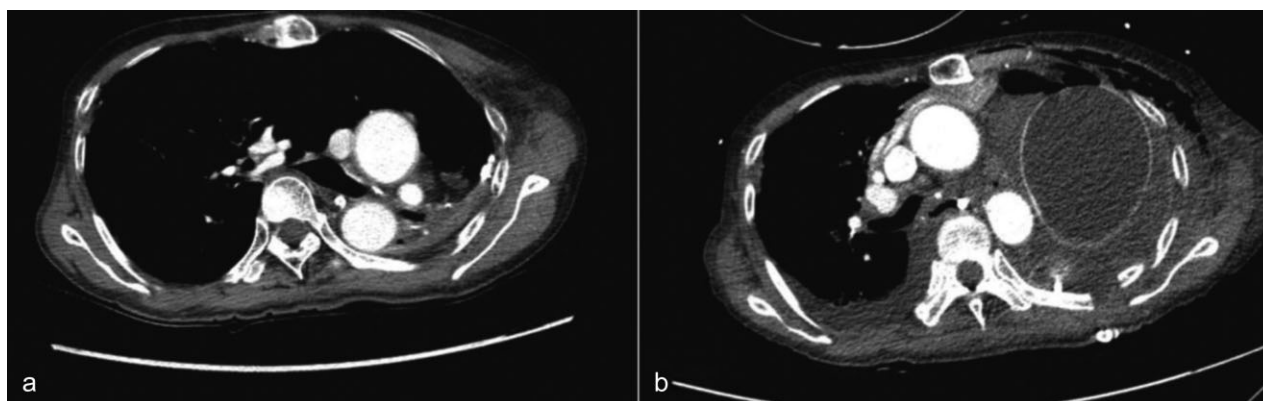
Preoperative and postoperative computed tomography scans of a patient. (a) The preoperative scan shows complete displacement of the mediastinum to the left chest. (b) The postoperative scan shows a well-positioned tissue expander with a midline mediastinum.
